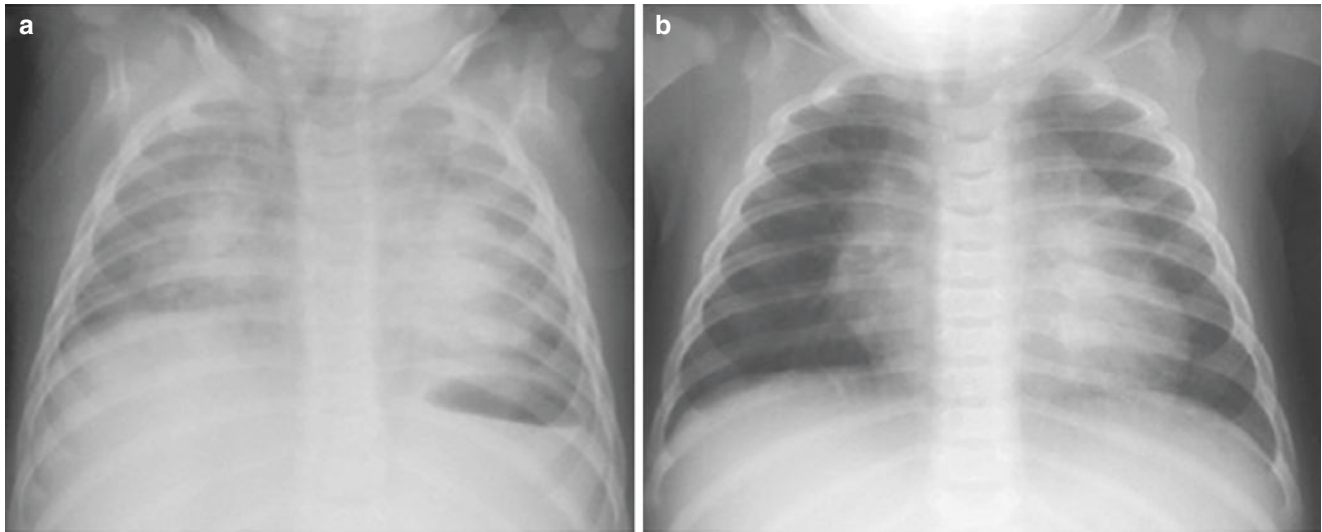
(a, b) Expiratory and inspiratory radiographs with posterior rib fractures. These two frontal radiographs on the same patient emphasize the importance of lung volumes when interpreting a chest radiograph. The first frontal radiograph (a) is performed in expiration, as
